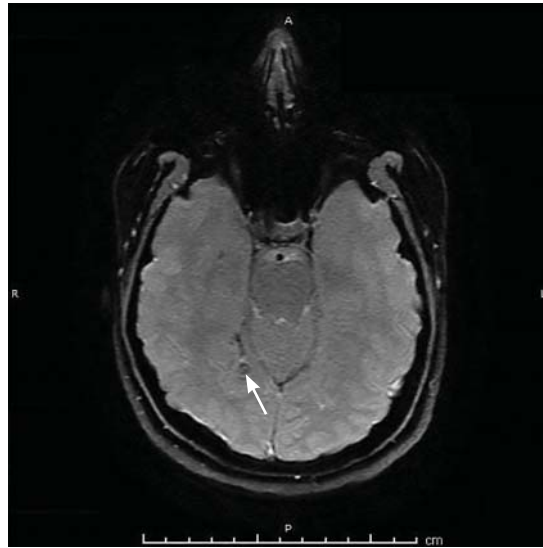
Susceptibility-weighted magnetic resonance imaging 3 years later for a flare in migraines showed a healed, indolent, right-occipital neurocysticercotic lesion and no evidence of an active process.
